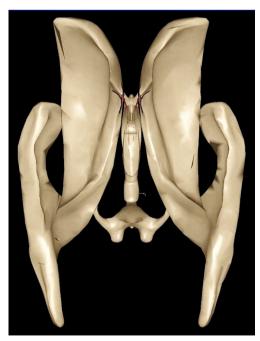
VR patient-specific ventricular system rendered from MRI, view from the bottom surface
